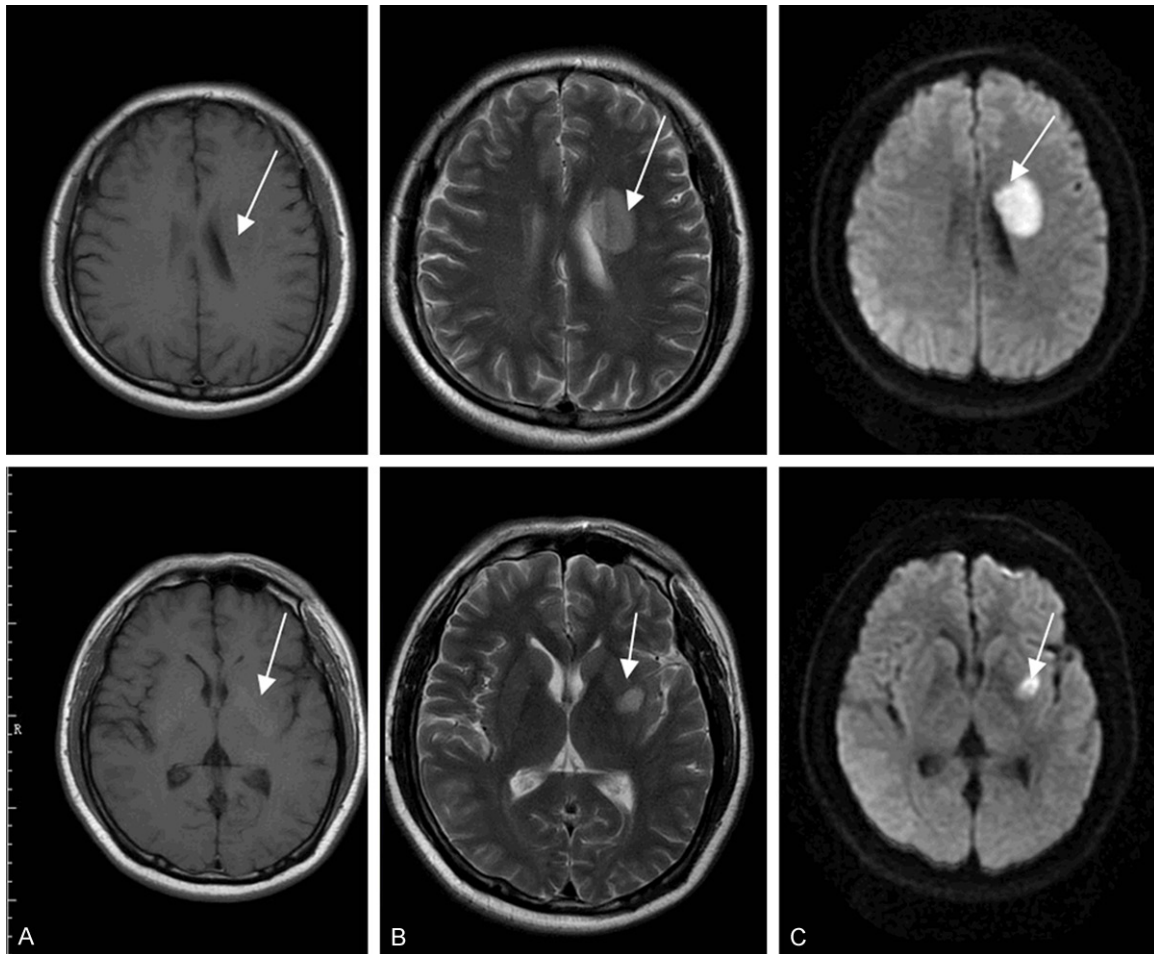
MRI slice scan showed damage (arrow indicated) in the area of left basal ganglia, A-C represented T1, T2 and diffused weighted image.
